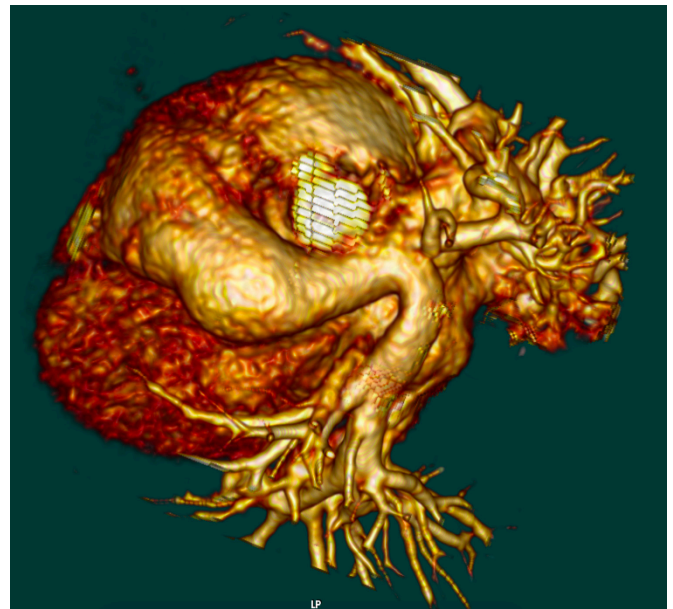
Computed tomography three-dimensional reconstruction demonstrated left pulmonary artery abnormally originated from right pulmonary artery.
